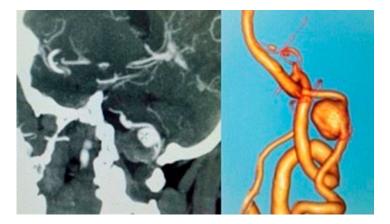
On the left-CT angiogram of a partially thrombosed aneurysm. On the right- CT angiogram of a PICA aneurysm. Source: Figure by authors.
